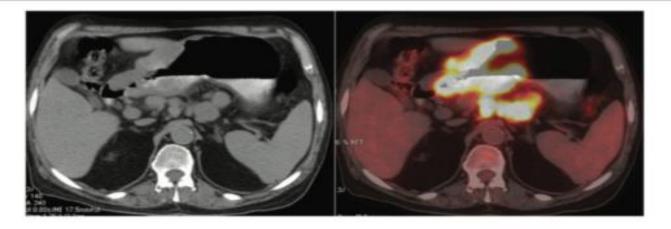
NHL showing intense FDG uptake in the anteropyloric region of the stomach along with perigastric lymph nodes in a 70-year-old man. Gastric lymphomas are usually associated with H. pylori gastritis.
